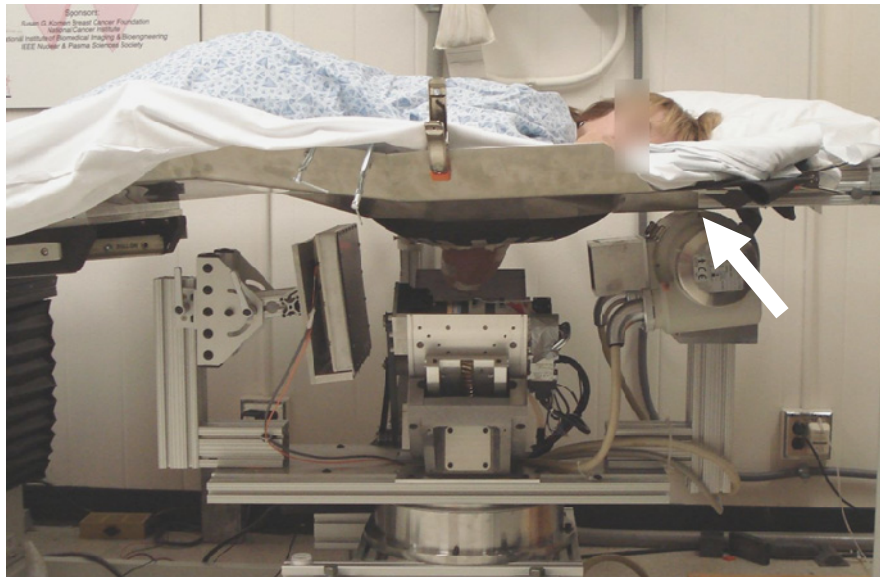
Image of the prototype integrated 1st iteration SPECT-CT imaging system with the tilted CT system visible while imaging a prone patient. In this photo, the bed is tilted slightly and raised (arrow) to allow the CT system to pass underneath the head section of the bed, thus separating the top plane of the cone beam farther from the chest wall.
